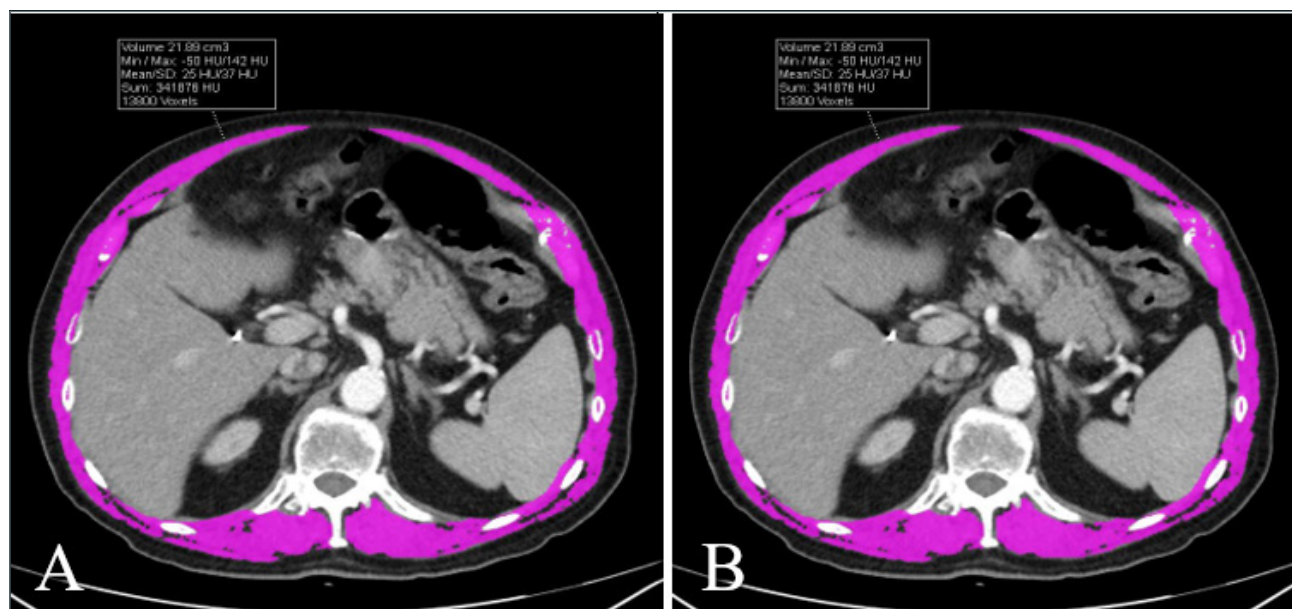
Semiautomatic segmentation of muscles on axial CT imaging at Th12 (A) and Th 10 (B) levels (pink). The volume of the segmented area was calculated automatically. The cross-sectional area measurement was performed via the following formula $\text{cm}^3 \times (10/\text{slice thickness in mm})$. Mean muscle density (Hounsfield Unit) was calculated automatically after segmentation.
